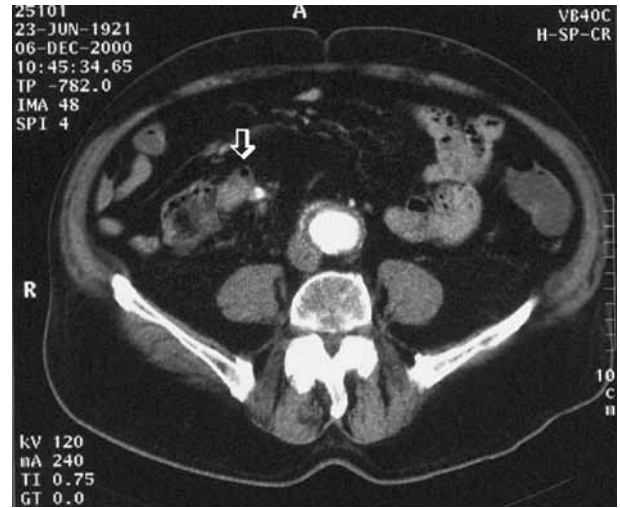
CT scan: Exophytic mass (20x15mm) of the last ileal loop and cecum with mesenteric retraction. Abdominal aortic aneurysm.
